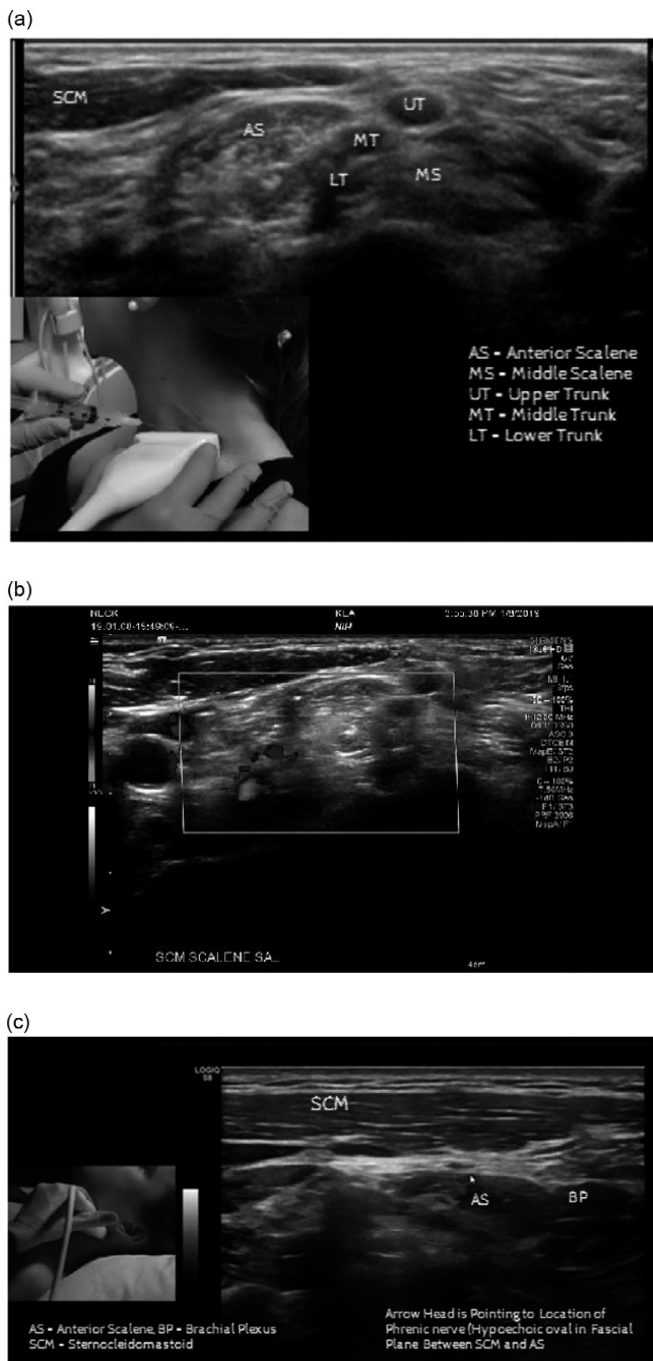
(a) Short-axis B-mode US image, interscalene triangle. (b) Short-axis color Doppler Image, interscalene triangle. (c) Short-axis B-mode image demonstrating relationship between phrenic nerve, SCM, and anterior scalene. AS: anterior scalene, BP: brachial plexus, UT: upper trunk, MT: middle trunk, LT: lower trunk, MS: middle scalene, SCM: sternocleidomastoid.
